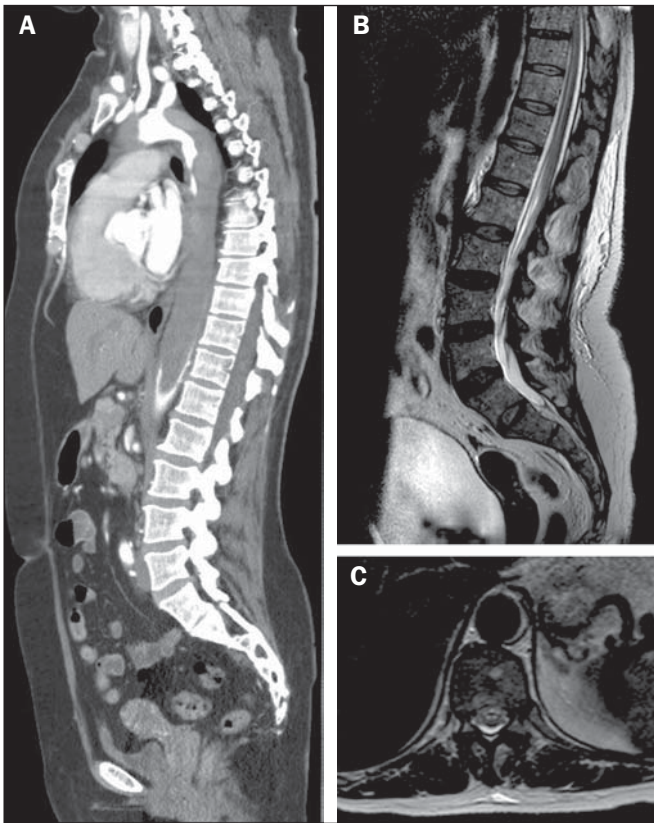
A: Maximum intensity projection reconstruction of computed tomography angiography in the sagittal plane showing an extensive mural thrombus in the thoracic aorta, extending to the infrarenal aorta. B: Sagittal T2-weighted MRI sequence showing areas of hyperintensity within the anterior spinal cord. C: Axial T2-weighted MRI at the level of the T10 spinal segment demonstrating anterior areas of hyperintensity, with the "owl eye" sign.
